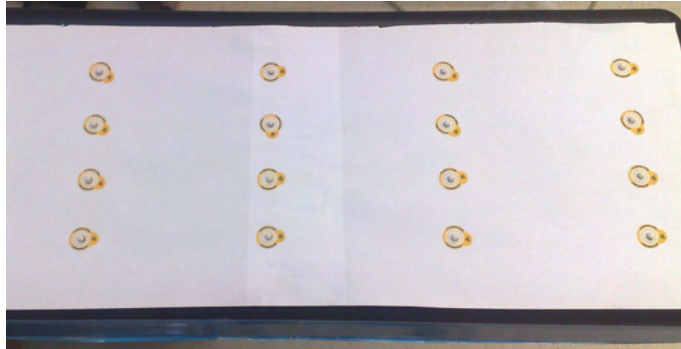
The X-ray marker pattern used for metric measurements.
